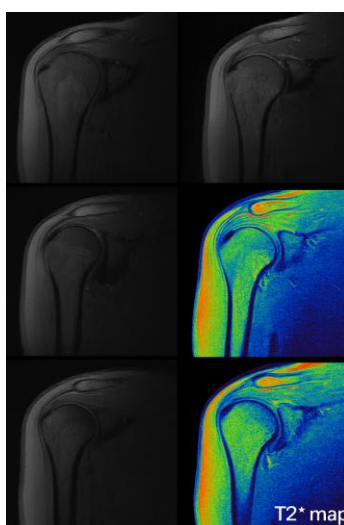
Multiplanar MRI and T2* mapping demonstrating rotator cuff tendon degeneration.
